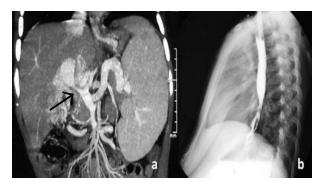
Enhanced computed tomography showing severe stenosis of the main portal vein (white arrow) and dilation of the splenic vein and coronary vein (a); and Barium swallow showing venous beading at the bottom of the esophagus indicating a dilated venous shunt (b).
